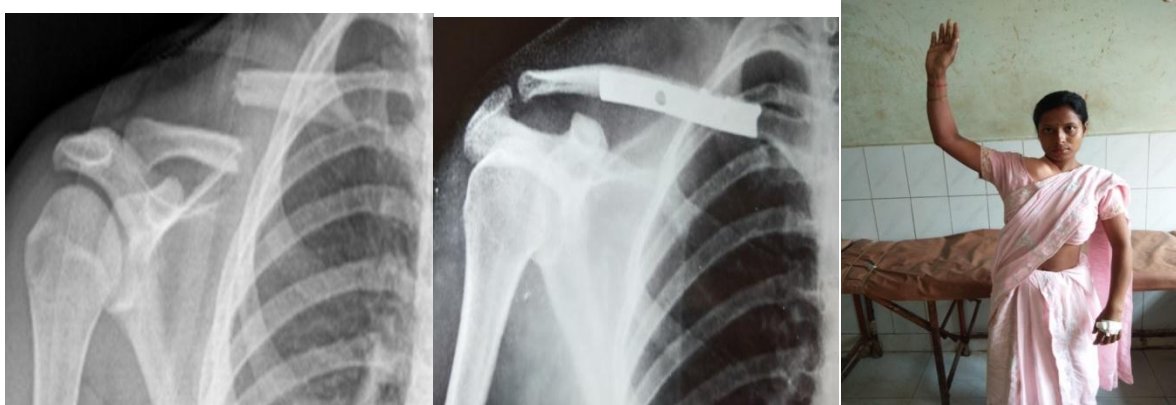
A. preoperative x-ray
